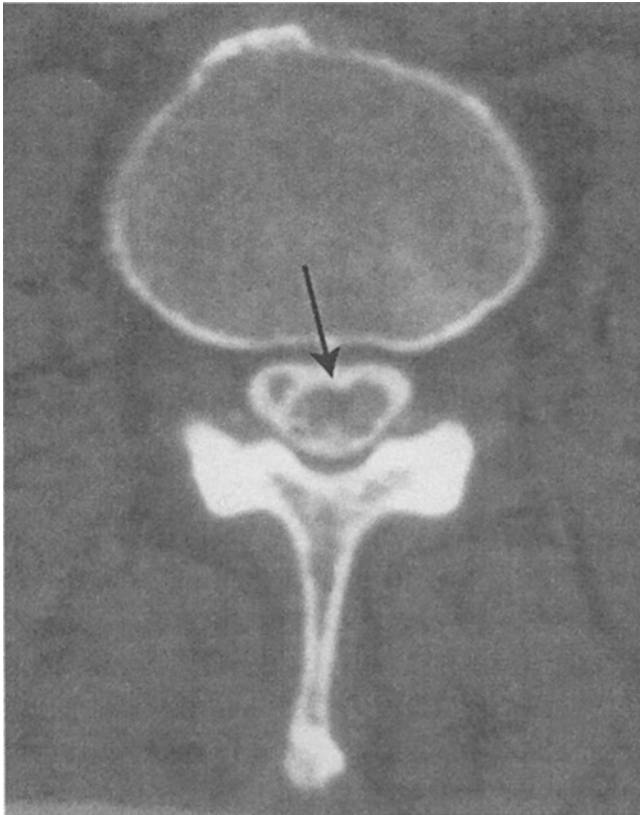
CT image through the second lumbar vertebra after intrathecal contrast injection (CT myelogram), showing arachnoiditis. The nerve roots are thickened and clumped together in a mass (*arrow*)
